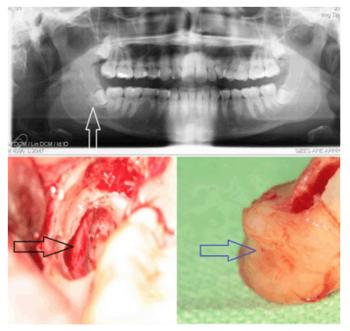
The panoramic radiograph showing "dark band" specific risk sign on the right impacted third molar's roots (white arrow). After tooth removal, the inferior alveolar nerve (more exactly the neurovascular bundle) became visible (black arrow). The groove formation of the removed tooth's roots (blue arrow) explains the radiographic "dark band" formation; inferior alveolar canal caused groove lets more radiation through the molar tooth.
